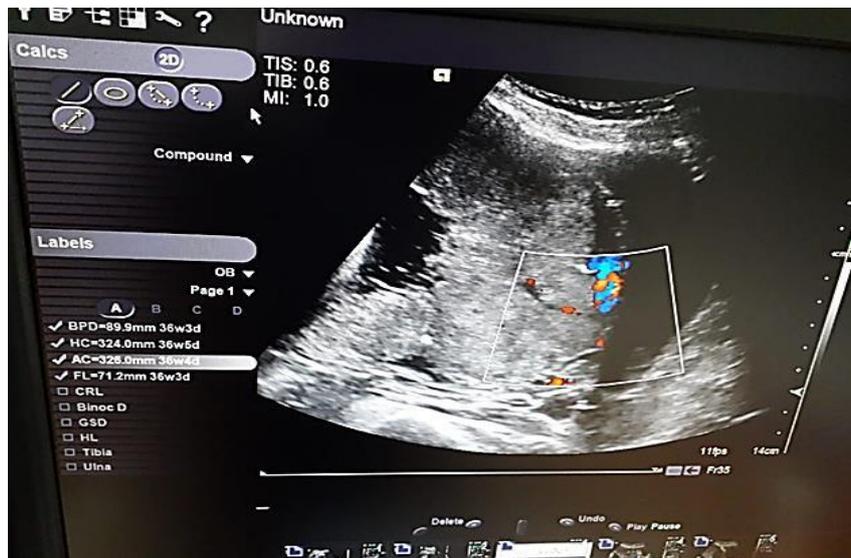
Ultrasound imaging showing Presence of placental lacunae and loss of the clear zone and bladder wall interruption plus uterovesical hypervascularity
